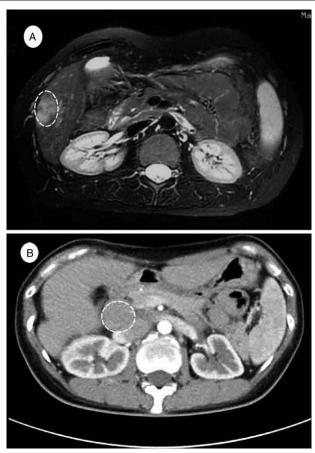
(A) Liver magnetic resonance image shows a small lymphoepithe-lioma-like cholangiocarcinoma at segment 6 of the liver (in-phase T1-weighted image). (B) CT shows metastasis of LEL-CC. CT=computed tomography, LEL-CC=lymphoepithelioma-like cholangiocarcinoma.
